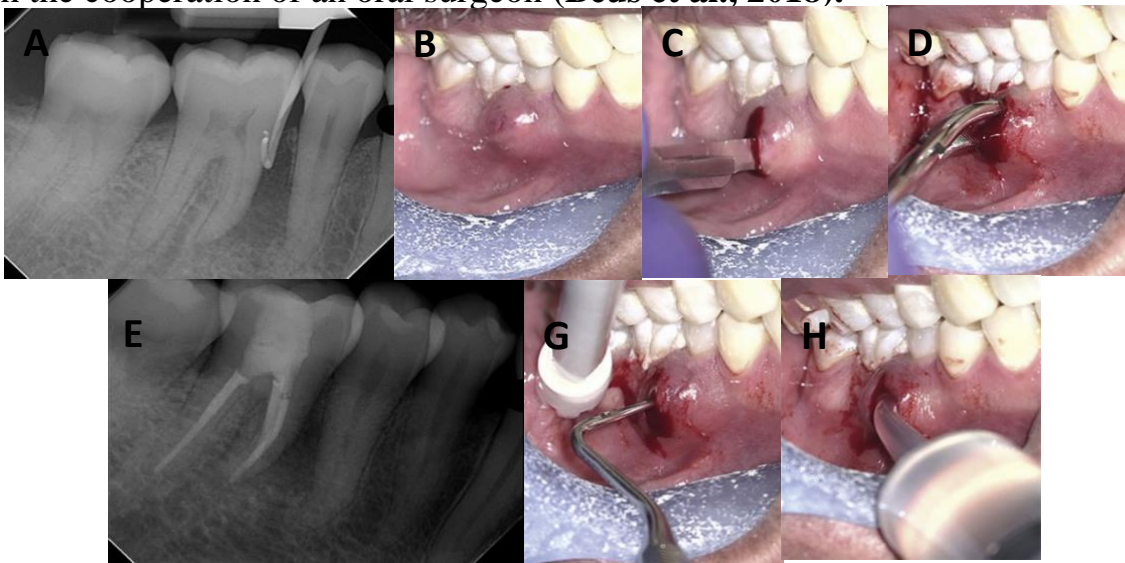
Management of pulp necrosis with acute apical abscess with localized intraoral swelling for a 60-year-old female patient with pain at 5/5 on visual analog scale (VAS). A, Preoperative radiograph of #30 with sulcular sinus tract. B, Preoperative photograph of intraoral swelling. C, Photograph of incision. D, Blunt dissection. E, Postoperative radiograph of completed obturation and access restoration at second visit. F, Curettage. G, Sterile saline irrigation. (Courtesy Dr. Saeed Bayat, UTHSCSA, San Antonio, TX, USA.)
